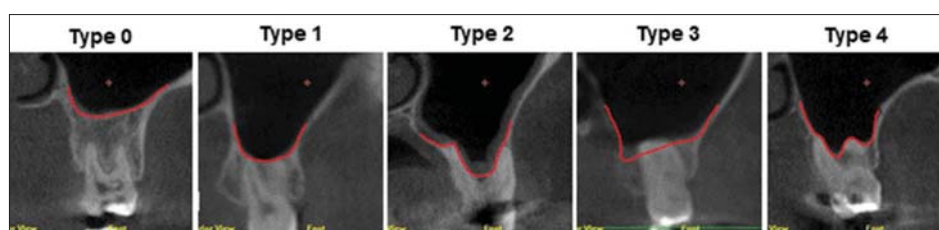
Cross-sectional cone-beam computed tomography images of 5 classifications of the maxillary posterior teeth roots relative to the adjacent floor of maxillary sinus¹⁶
